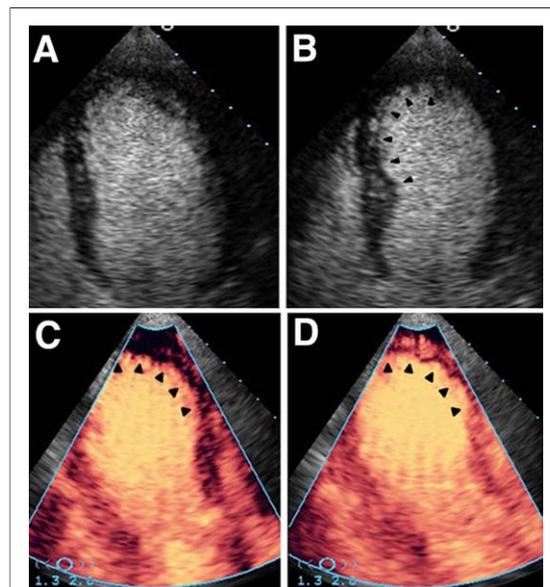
Echocardiographic Images of a Patient With CP
